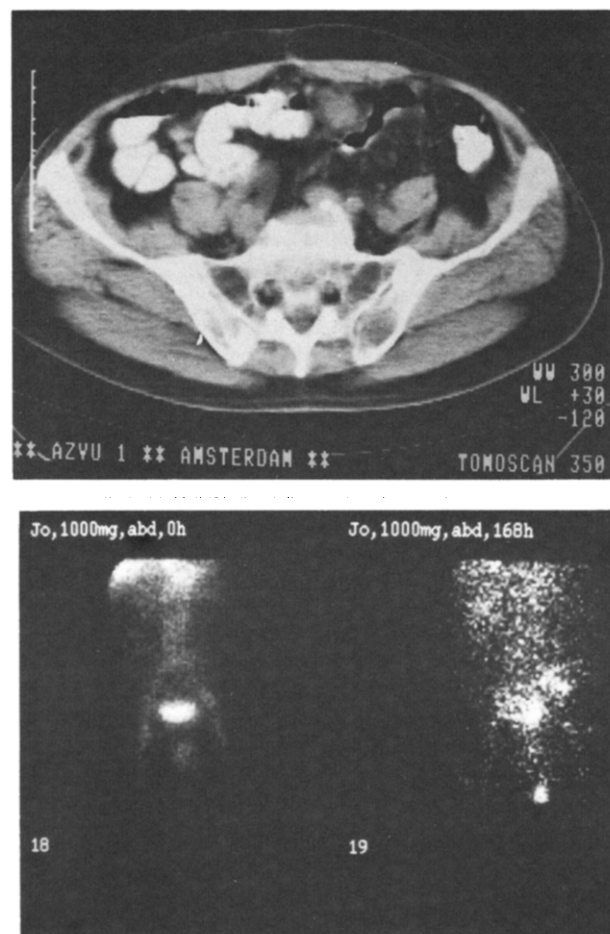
Patient IV-4 had a positive area at the left side of the urinary bladder on the immunoscintigram (anterior view) at day 7 (lower); CT at that time did not reveal abnormalities (upper).
